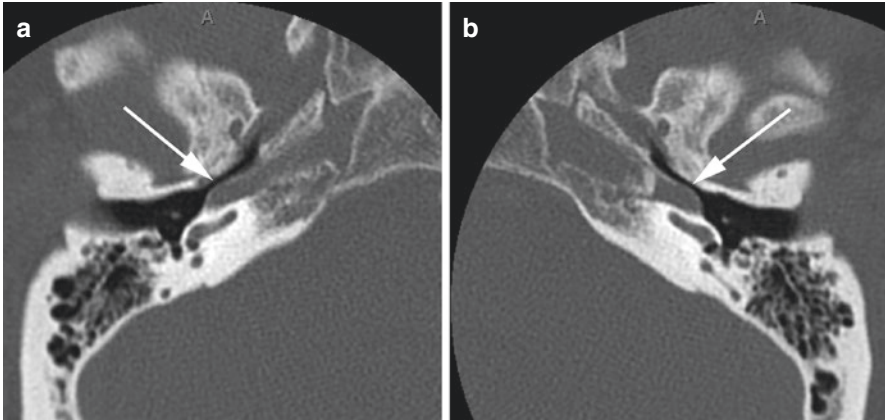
Lateralized internal carotid artery. Patient with asymptomatic bilateral lateralized ICA's. Noncontrast CT of the temporal bones right (a) and left (b) ICA's coursing along the cochlear promontories (arrows), but without a persistent stapedial artery or enlarged tympanic canaliculus
